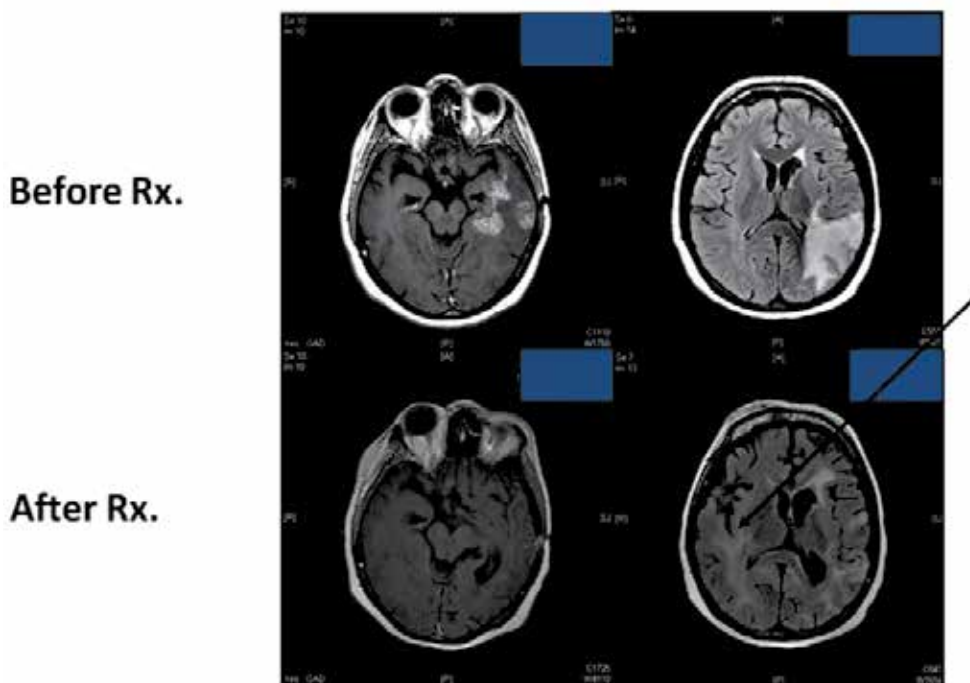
Demonstration of response to bevacizumab in recurrent glioblastoma. Top two panels reflect an axial T1 enhanced and axial FLAIR image from a 43 year old woman with recurrent GBM before first infusion of BEV while the bottom two panels represent imaging performed after third infusion. Note the marked improvement in enhancement and amount of mass effect after treatment. However, there is now an increased area of T2 FLAIR abnormality distant from original site of relapse (Arrow). This represents new infiltrative tumor.
